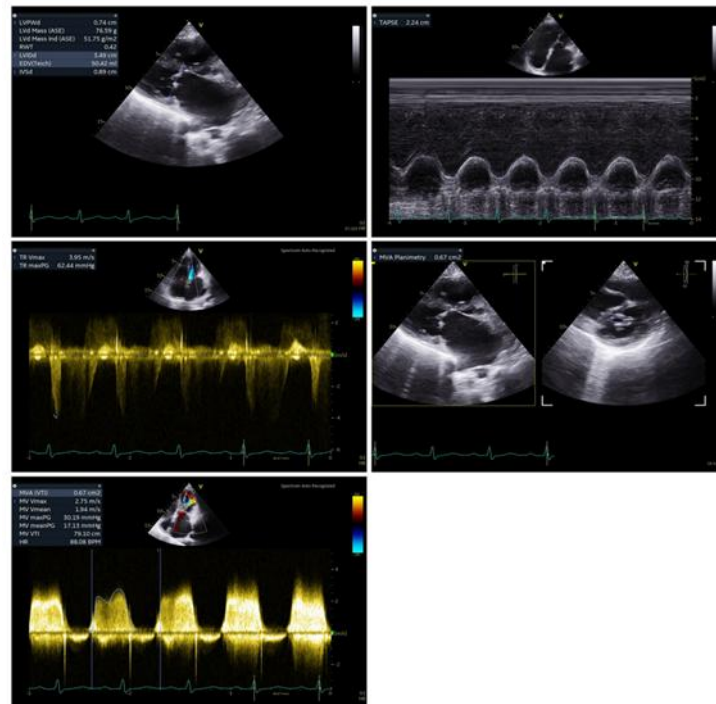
Echocardiography showed LA and LV dilation, reduced EF (54.38%), uncoordinated septal wall motion, severe mitral stenosis (MS), mild tricuspid regurgitation, high probability of pulmonary hypertension, and undetermined diastolic function due to severe MS.
